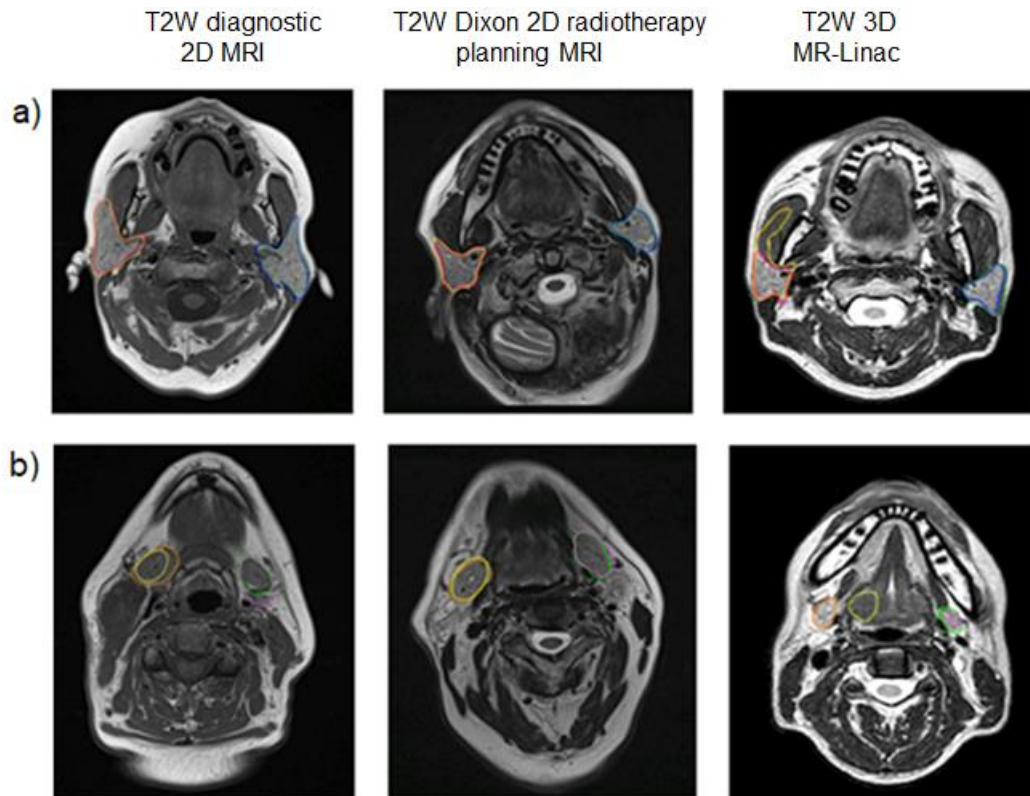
Spatial overlap of contours between model_{MRI} automated contours and manually drawn contours for the 3 types of MR. (a) right and left parotid glands (b) and submandibular glands
